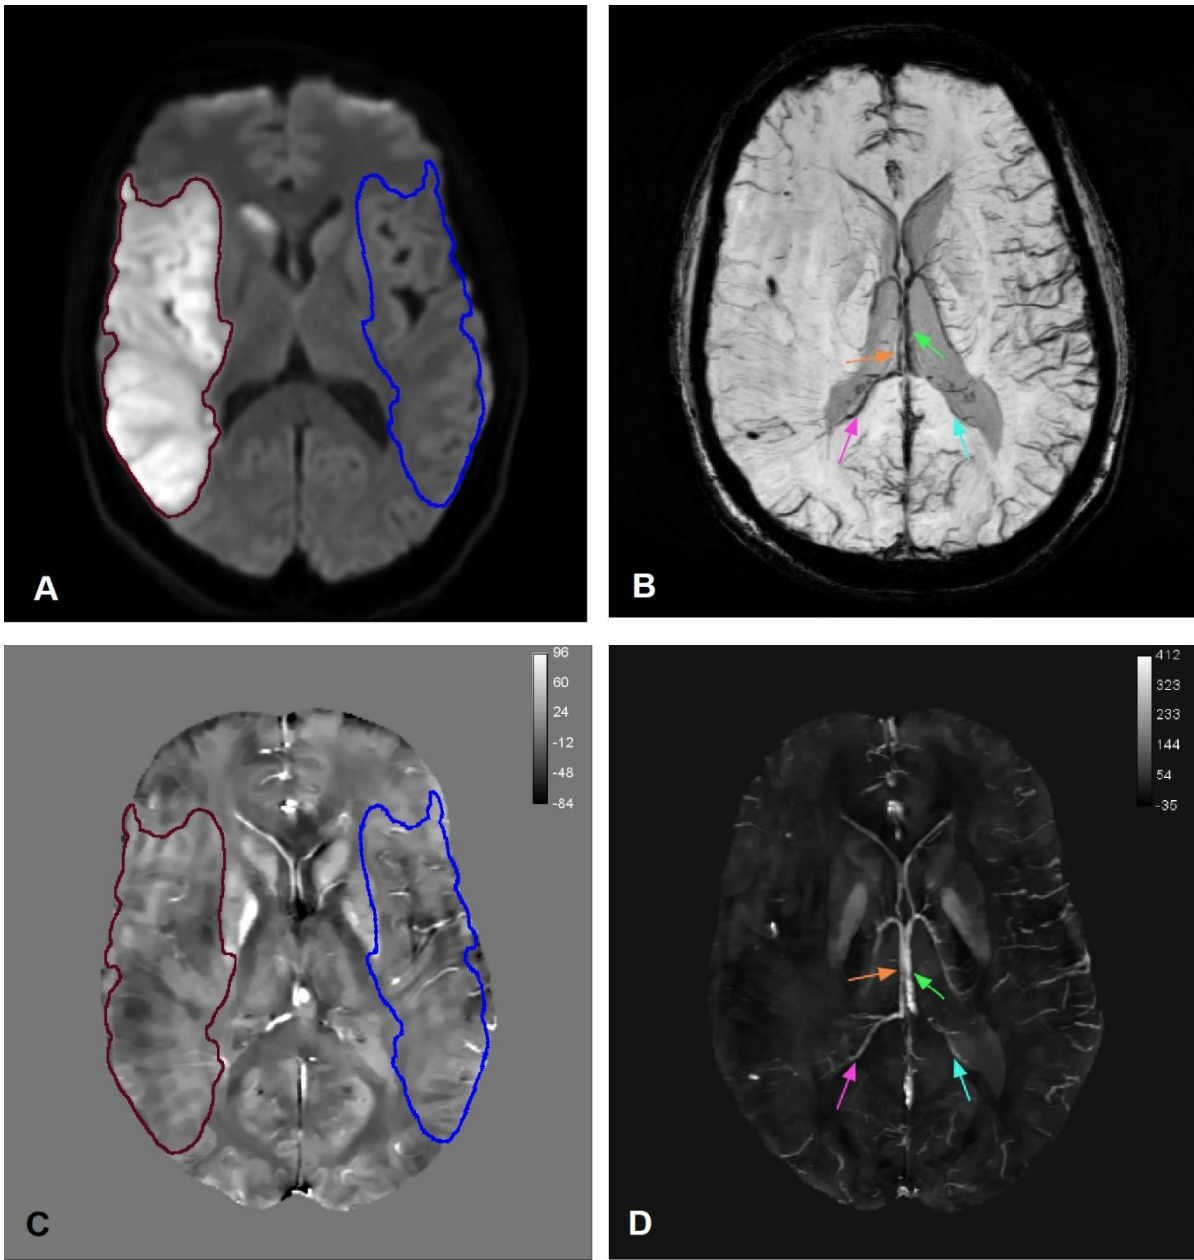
Images from an ischemic stroke subject: DWI (A), minimum Intensity Projection SWI (B), QSM (ppb) (C), Maximum Intensity Projection QSM to show veins (ppb) (D). Infarcted region (red) and homologous region (blue) are shown on DWI and QSM (A, C). Also, local veins (pink) and major veins (orange) in infarct territory and contralateral hemisphere (cyan for local vein and green for major vein) are depicted on mIP SWI and MIP QSM images (B, D). Also, note that in the infarcted region the tissue is destroyed, therefore it is likely that the tissue might not be getting as much perfusion/ the veins are dying/disappearing and hence fewer number of veins can be observed. The measurements were taken from present local veins in the infarcted region and contralateral region.
